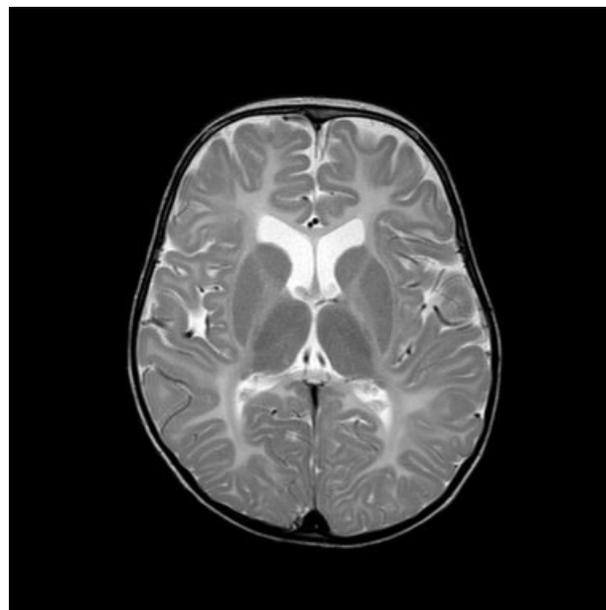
T2 axial magnetic resonance imaging at age 21/2 years showing diffuse hypomyelination of the internal capsules, subcortical white matter and deep white matter.
